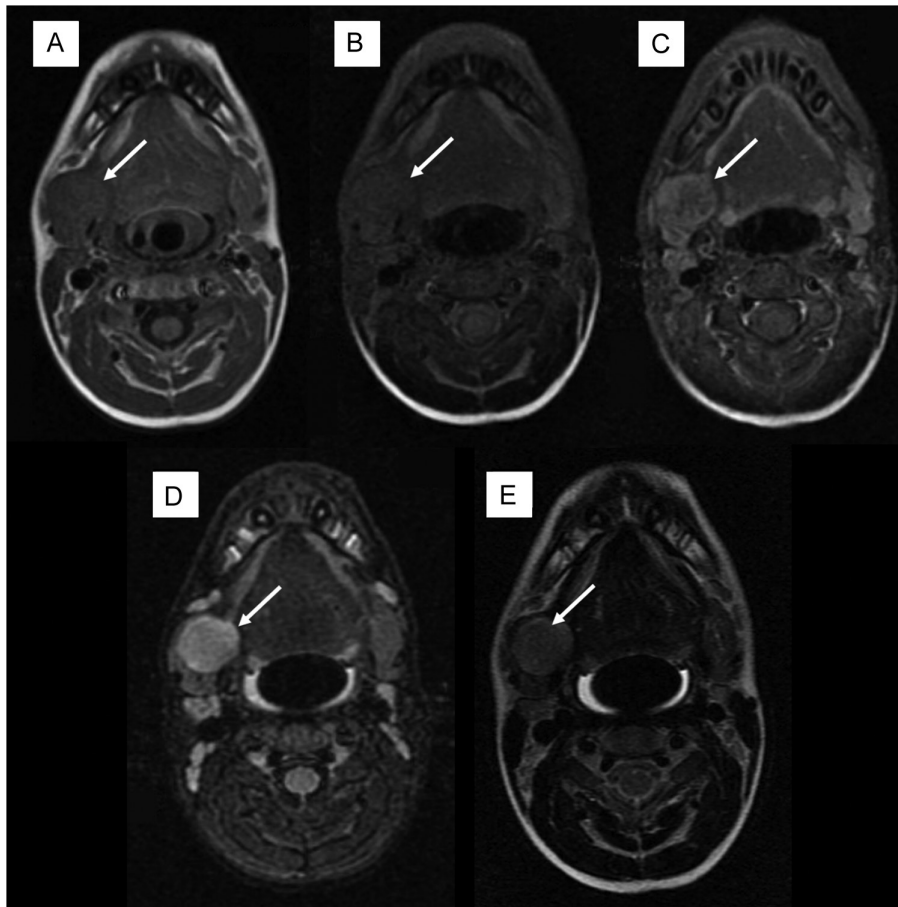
Magnetic resonance images. (A) Axial T1W and (B) fat-suppressed T1W sequences demonstrate a rounded and well demarcated mass centered to the right submandibular gland, measuring 20 × 19 mm. (C) After administration of gadolinium, this mass shows diffuse contrast enhancement on T1W sequences. (D) A high homogenous hyperintensity signal is evident on the fat-suppressed T2W sequence using *short tau inversion recovery* technique (E) when compared to T2W images (E).
